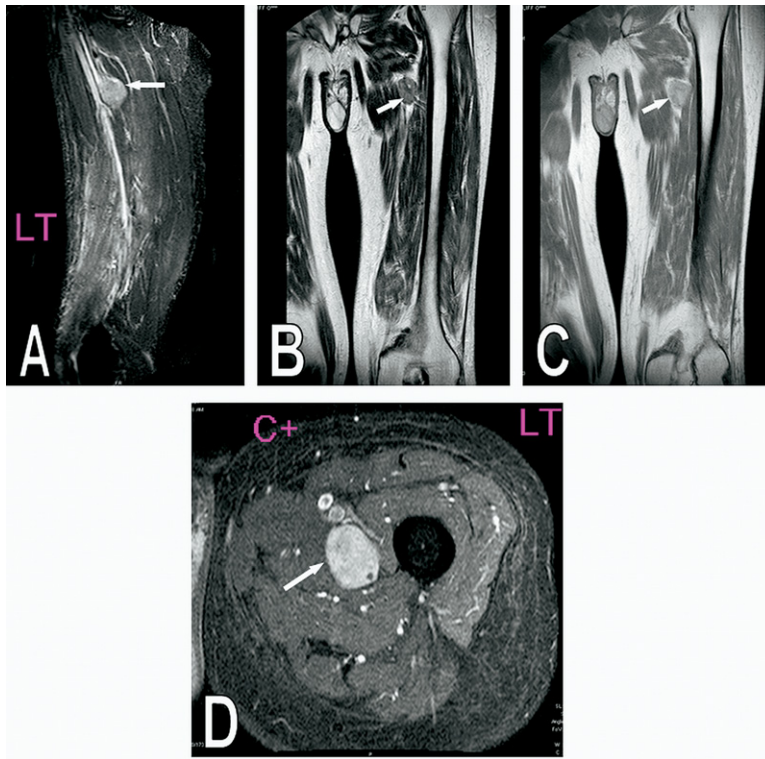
Magnetic resonance imaging (MRI) of the left thigh revealed a well-circumscribed, oval mass (*white arrow, A to D*) in the anteromedial thigh compartment and in close proximity to the femoral neurovascular bundle. Images (A) (*left lateral sagittal view*) and (D) (*axial view*) depict the T-1 weighted contrast-enhanced images of the tumor medial to the femur and immediately posterior to the femoral neurovascular bundle. Images (B) (*T-2 weighted*) and (C) (*T-1 weighted*) present the mass in a coronal plane.
